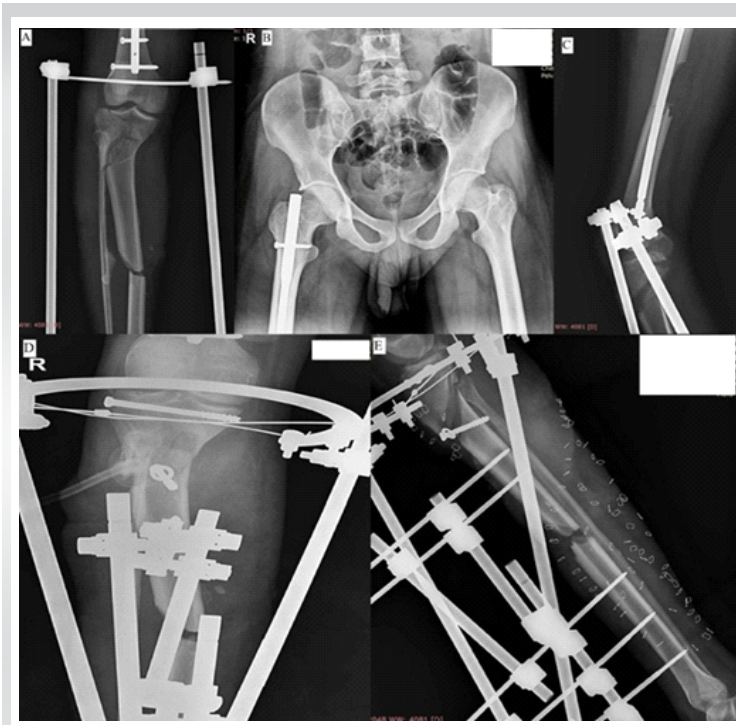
(a, b, c) X-rays of the patient at the time of hospital admission; (d and e) Immediate post-operative X-rays.
